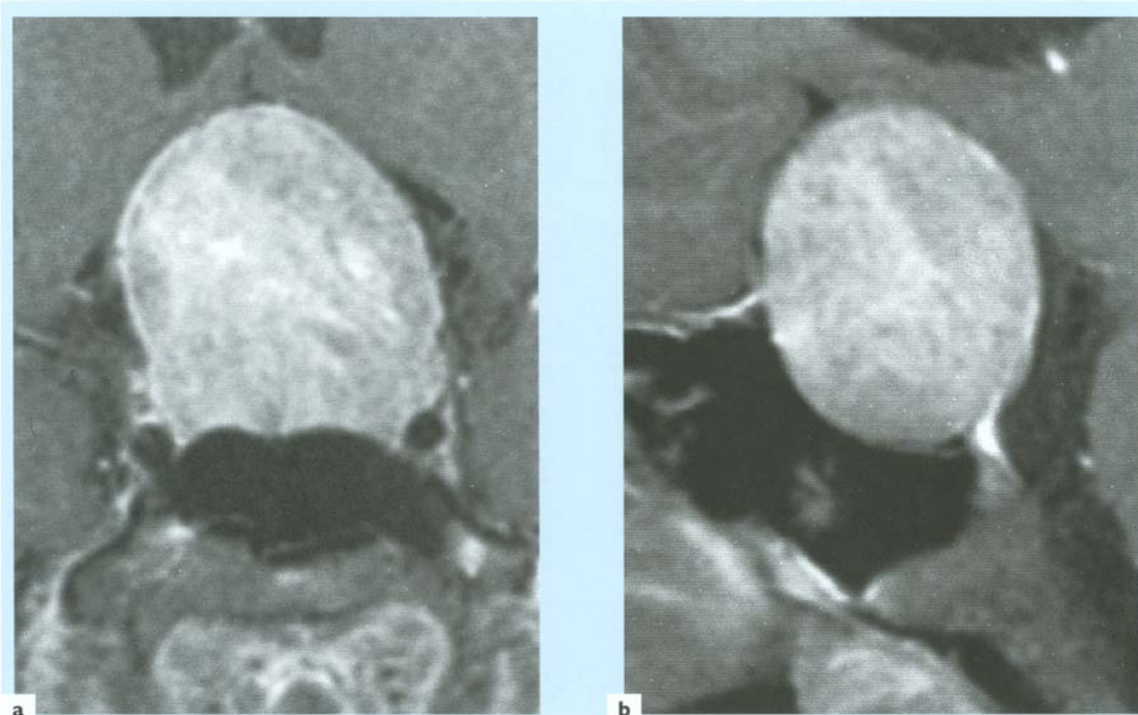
Magnetic resonance imaging with gadolinium enhancement ((a) anteroposterior view; (b) lateral view) of a pituitary tumor (chromophobe adenoma). This is a rare cause of erectile dysfunction, and is usually associated with elevated levels of prolactin and diminished levels of testosterone
